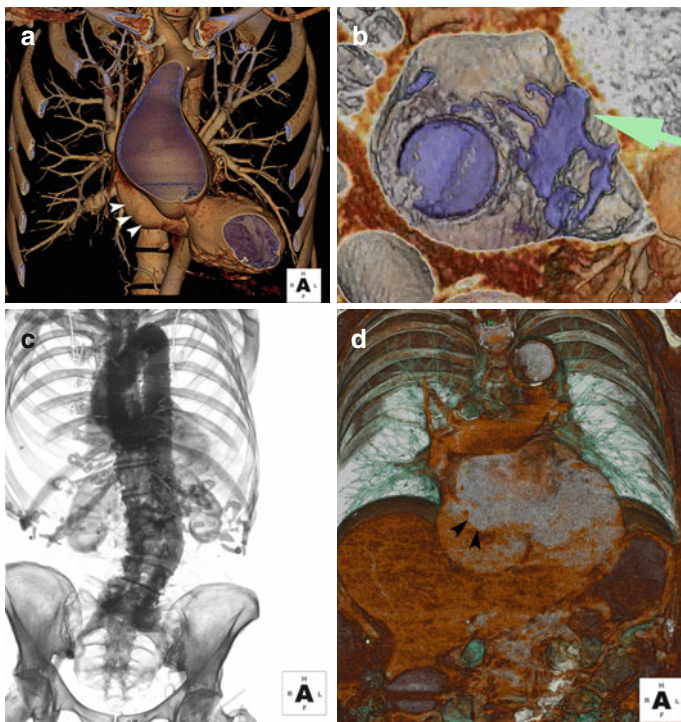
High-risk transseptal anatomy identified by CTA. (a) Extracardiac distortion by an ascending aortic aneurysm can cause bulging of the antero-superior aspect of the interatrial septum (IAS) (*white arrowheads*). (b) Extensive calcification (*green arrow*) of the IAS can be visualized in a postsurgical patient with limited location for transseptal puncture. (c, d) Patient with significant scoliosis leading to a more horizontal orientation of the IAS (*black arrowheads*)
